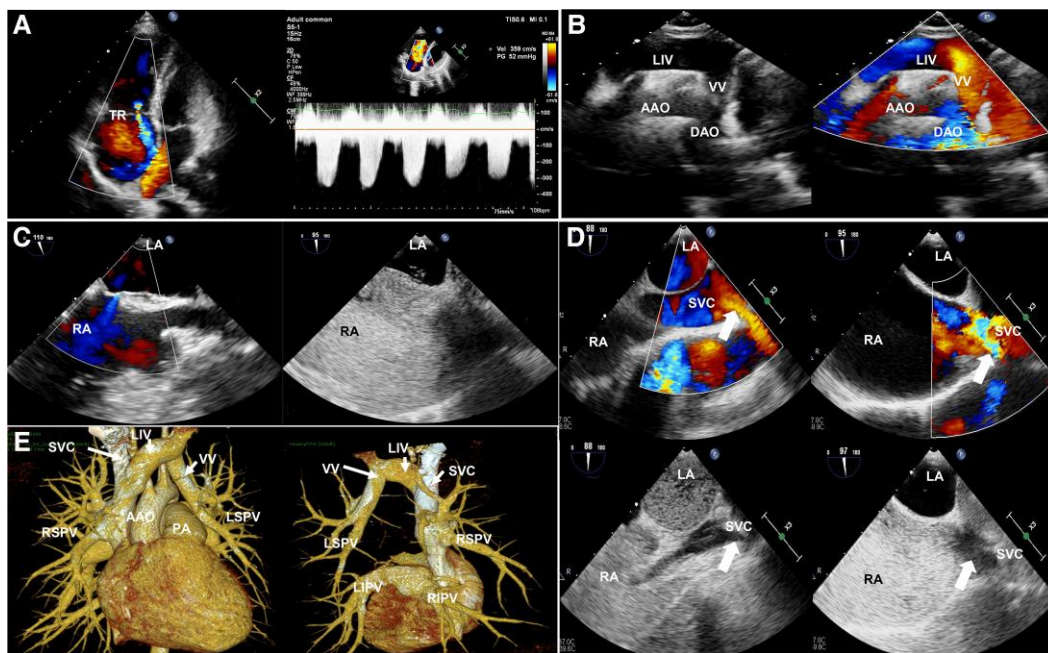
(A) Transthoracic echocardiography revealed enlarged right heart chambers with moderate tricuspid regurgitation, and the velocity of tricuspid regurgitation. (B) The suprasternal axis view showed an abnormal laminar continuous venous flow draining into the LIV. (C) TEE revealed a PFO. Colour Doppler revealed a left–right shunting, and right-heart agitated saline study shown an immediate passage of saline bubbles from RA to LA through the PFO. (D) TEE with colour Cooper, and negative saline contrast study revealed two separate bloodstreams that drained into the SVC. (E) A contrast-enhanced computed tomography image of PAVC. AA, aortic arch; AAO, ascending aorta; LA, left atria; LIPV, left inferior pulmonary vein; LIV, left innominate vein; LSPV, the left superior pulmonary vein; PA, pulmonary artery; PAPVC, partial anomalous pulmonary venous connection; PFO, patent foramen ovale; RA, right atria; RIPV, right inferior pulmonary vein; RSPV, right superior pulmonary vein; SVC, superior vena cava; TEE, transesophageal echocardiography; VV, vertical vein.
